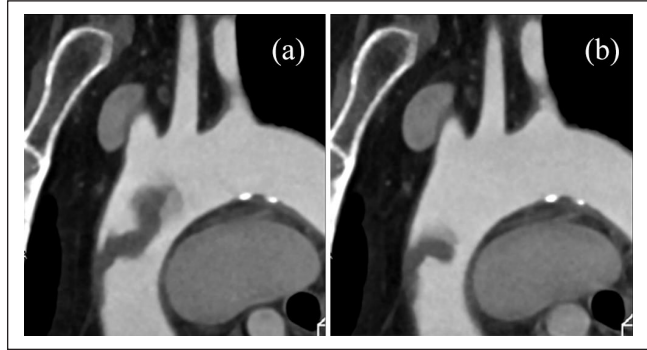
Four-dimensional CT images showed that the mass was attached to the anterior wall of the ascending aorta and moved up and down in sync with the patient's heartbeat: (a) systolic phase; (b) diastolic phase.
